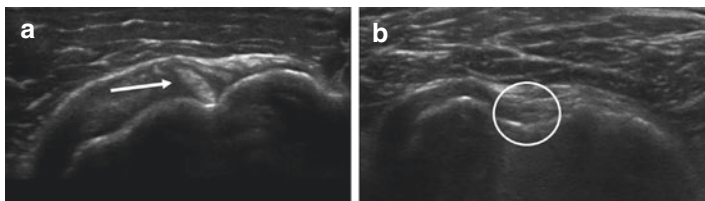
(a) Short axis ultrasound (US) showing the long head of the biceps tendon in the bicipital groove (*arrow*). (b) Short axis US in a different patient showing the absence of the LHB tendon in the bicipital groove (*circle*), indicating a complete tear of the tendon with distal retraction
